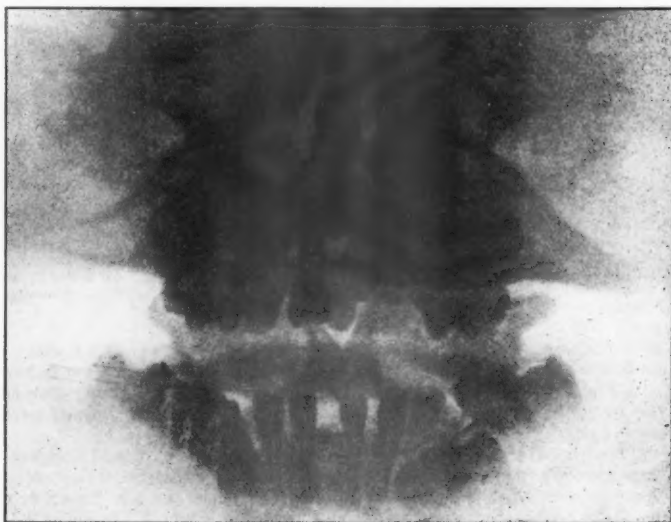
Radiograph showing an unerupted upper central incisor with well-marked notch. The incisor on opposite side has erupted and shows the same condition.
